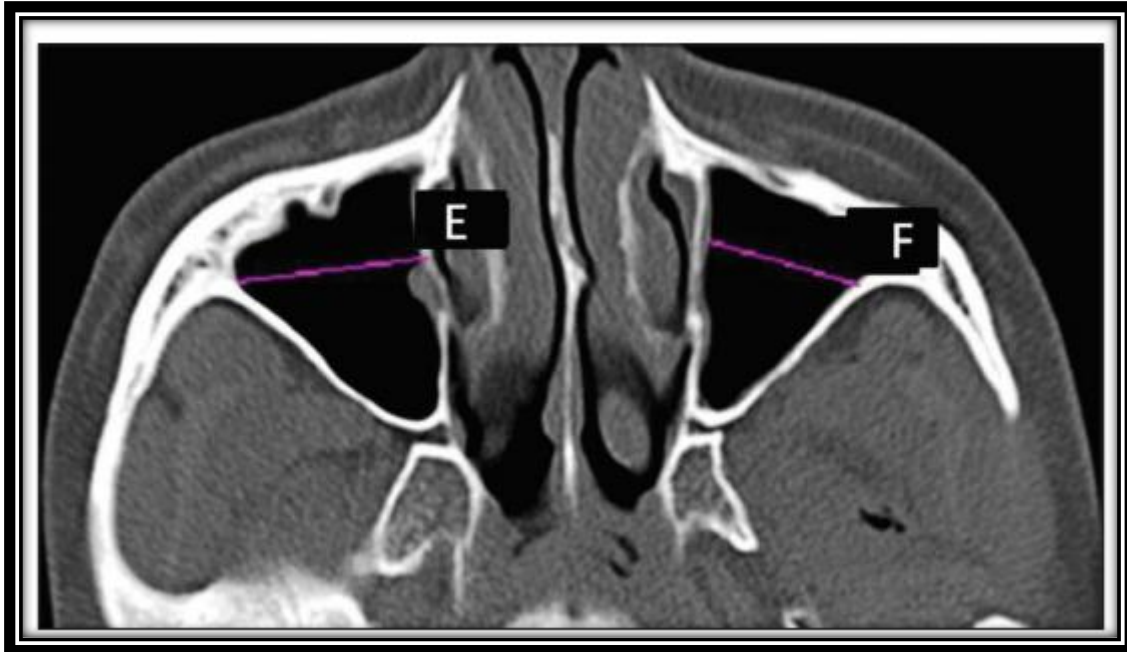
Axial view of computed tomography image showing maximal mediolateral diameter of maxillary sinus: (E) Right side, (F) Left side¹⁴
